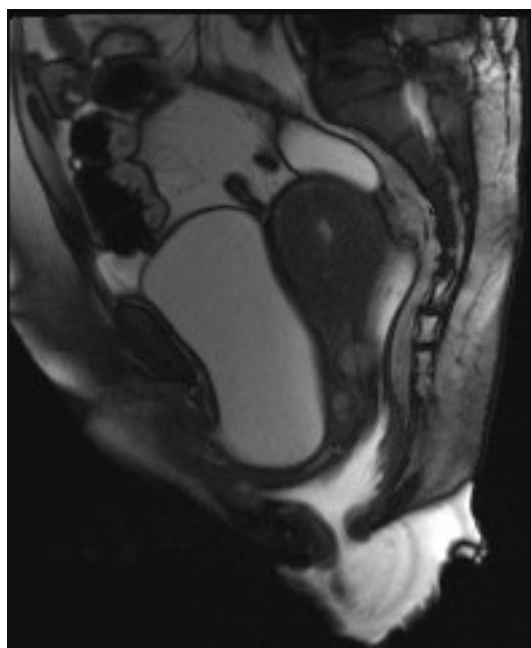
MRI defecography showing severe pelvic floor descent
